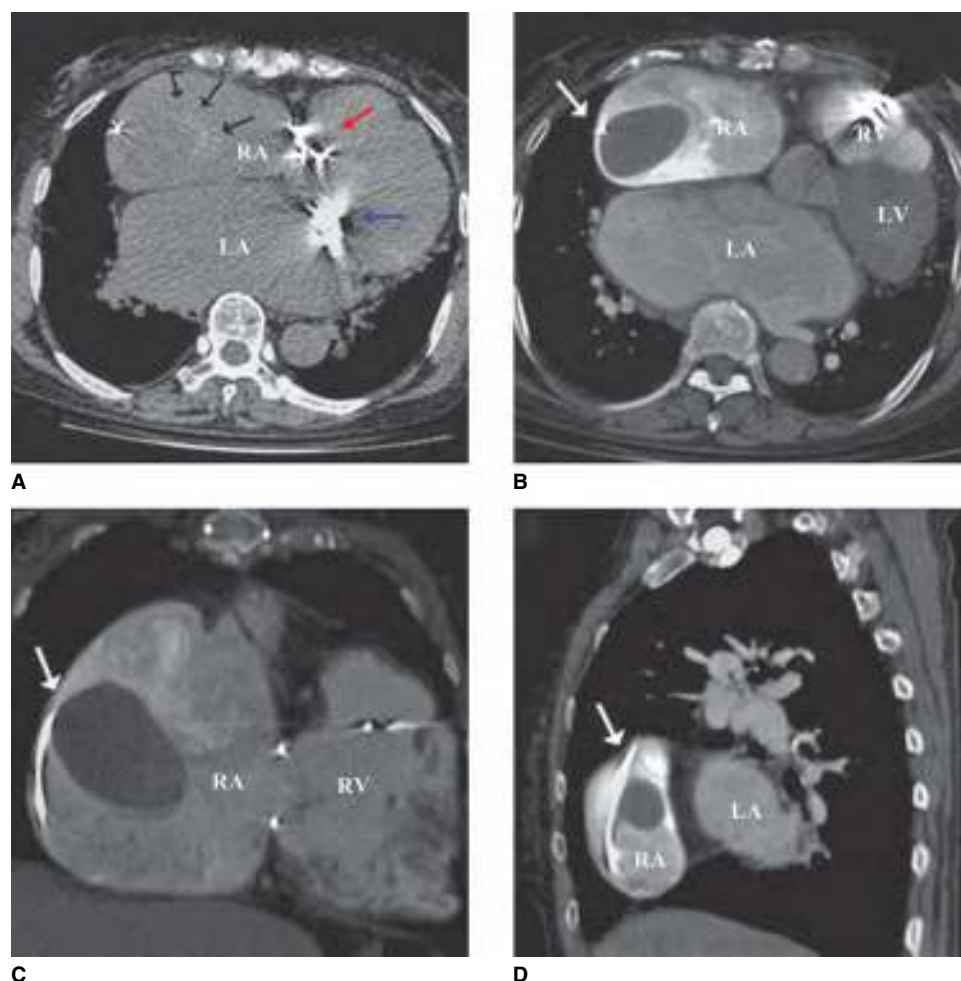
Chest CT angiography demonstrating a large mass attached to the lead (white arrows) in the right atrium. LA, left atrium; RA, right atrium. (Used with permission from reference 40.)
